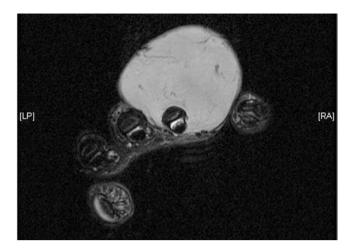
T2-weighted MRI image of a 5 cm true fibrosarcoma of the fourth metatarsal soft tissues and extensor tendons of the right third, fourth, and fifth digits
